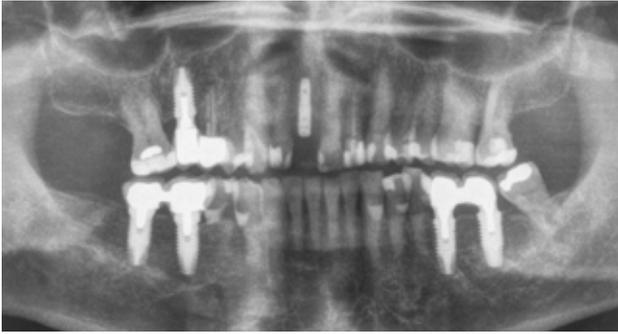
12 X-ray and Cone-Beam after bone regeneration
